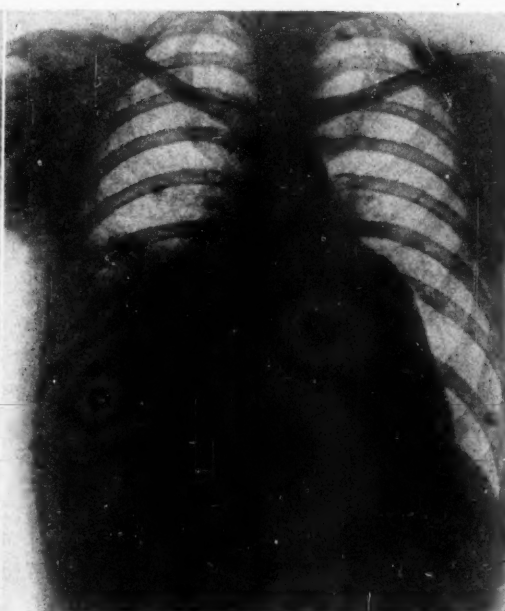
Roentgenogram made after patient developed foul expectoration. An increase in fluid may be seen and a definite fluid level may be noted in the third anterior interspace, indicating a pyopneumothorax and suggesting a putrid empyema.
